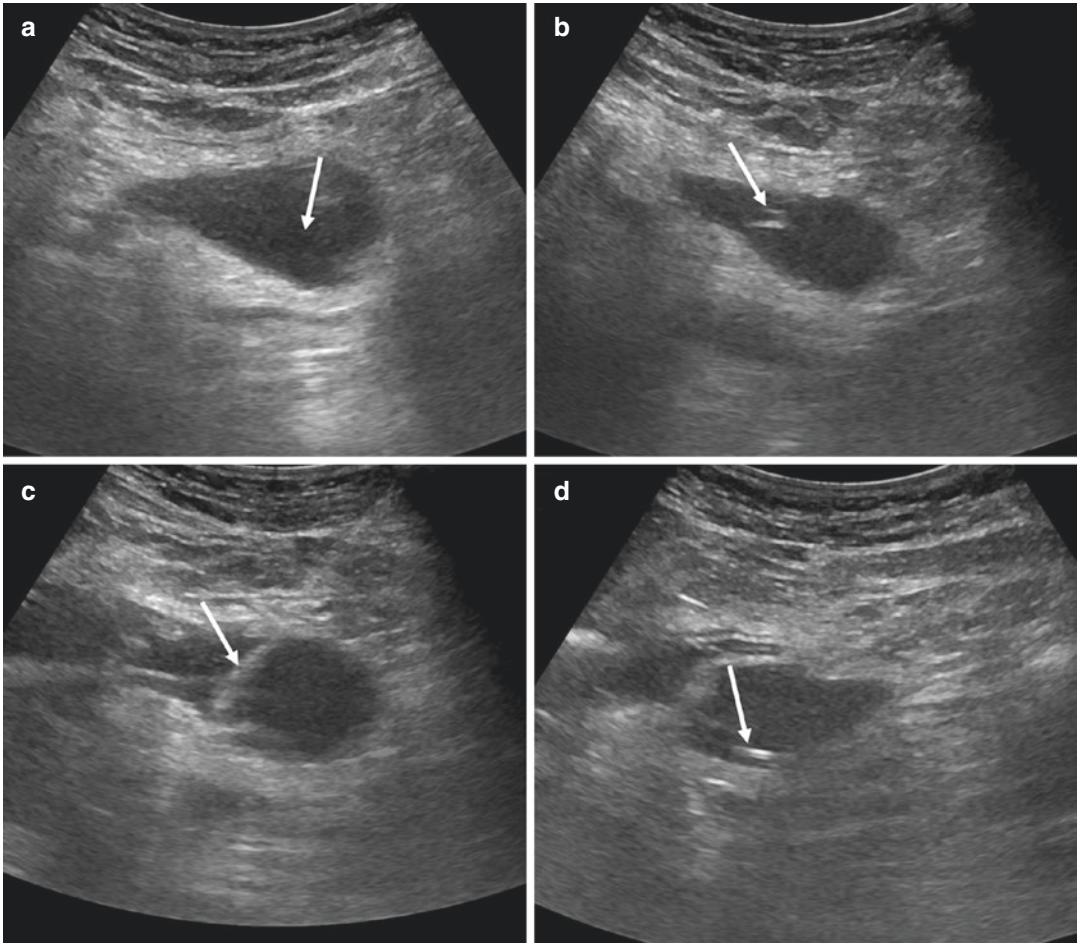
Seldinger technique for ultrasound-guided PCD of pancreatic fluid collection. (a) Fluid collection is seen in lesser sac (arrow). (b) Ultrasound-guided needle (arrow) insertion is performed. (c) A guidewire (arrow) is
